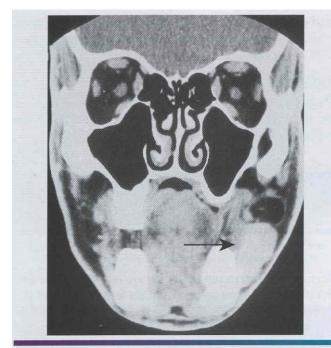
• Adult rhabdomyoma. Computed to mography (CT) scan of the same tumor depicted in Figure 12-116. Note the mass (*arrow*) lateral to the left body of the mandible. (Courtesy of Dr. Craig Little.)
